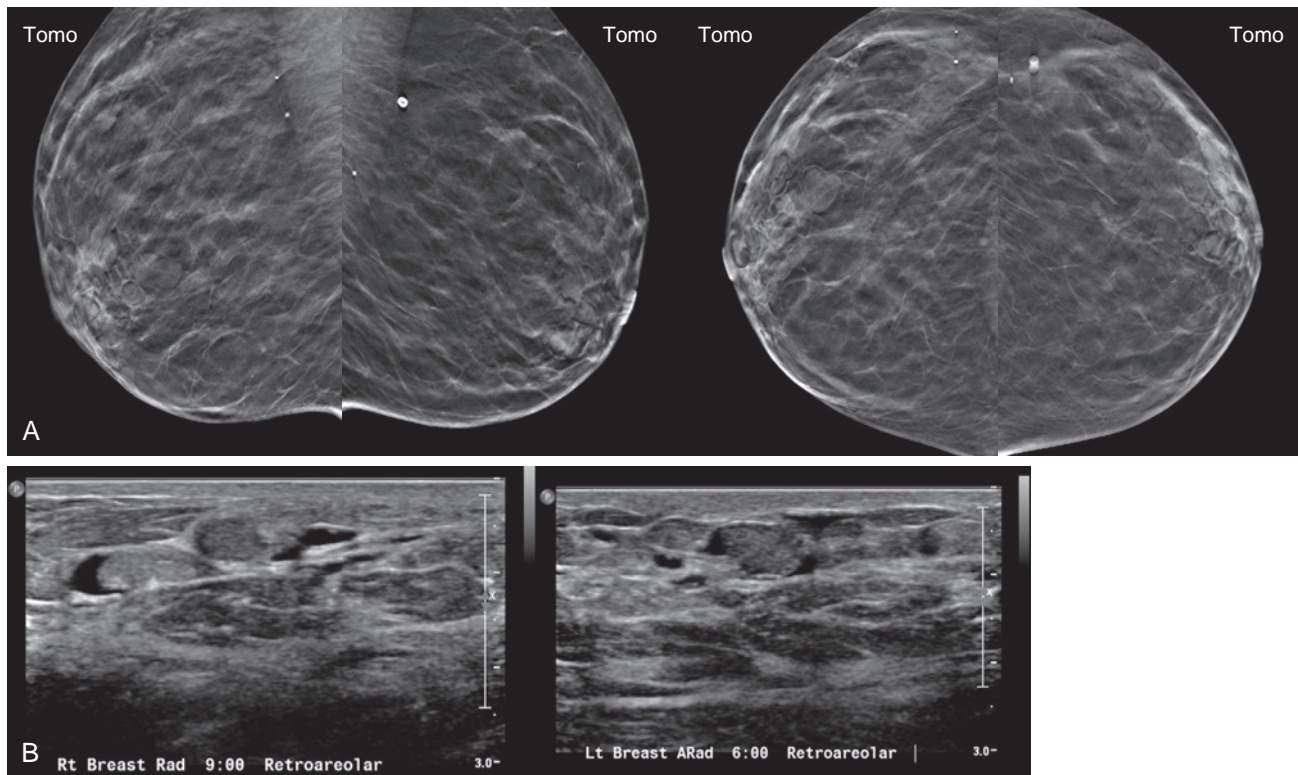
Duct ectasia. A 45-year-old woman with heterogeneously dense breast tissue presented for routine screening. (A) Tomosynthesis views demonstrate multiple dilated ducts and associated intraductal densities bilaterally, which were not appreciated on two-dimensional imaging. Screening ultrasound performed concurrently demonstrates multiple dilated ducts containing echogenic debris without associated internal vascularity. In this asymptomatic patient, continued routine screening was recommended.
